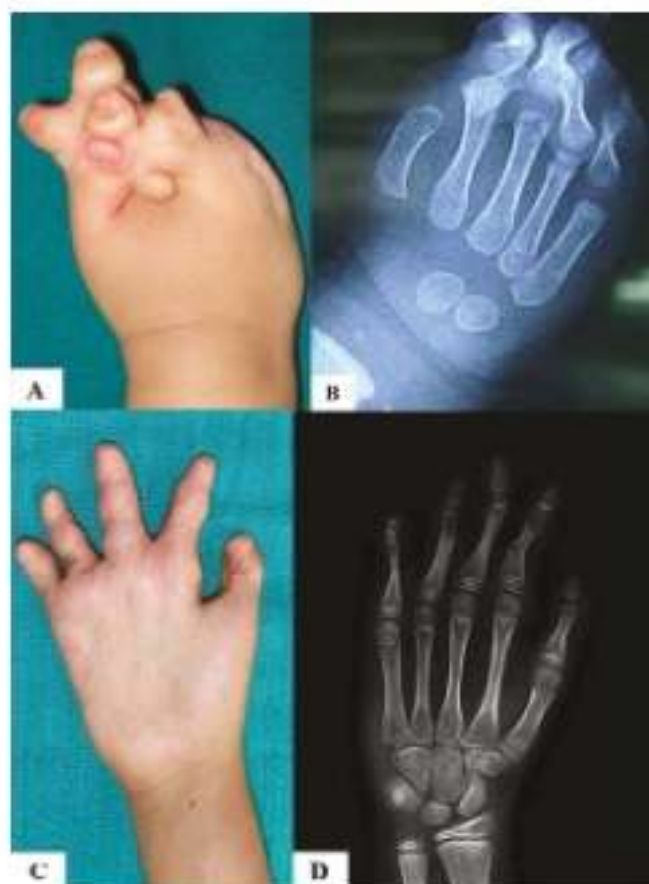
Scrambled type of acrosyndactyly. (A and B) Pre-operative photograph of the complex acrosyndactyly with radiograph. The child has undergone four operations to achieve a five-digit hand as shown in C and D. Final follow-up photograph and radiograph were taken 10 years after the first surgery.
